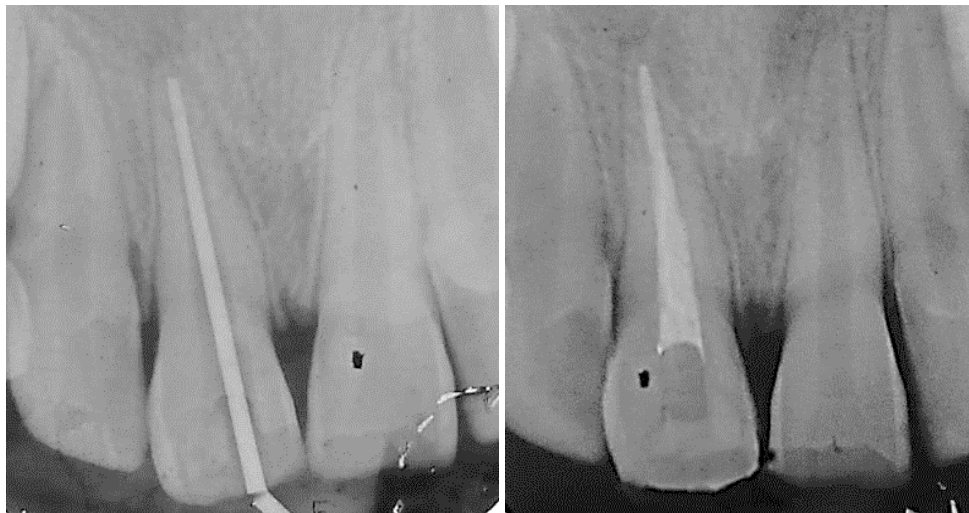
Master cone radiograph and Obturation done.
